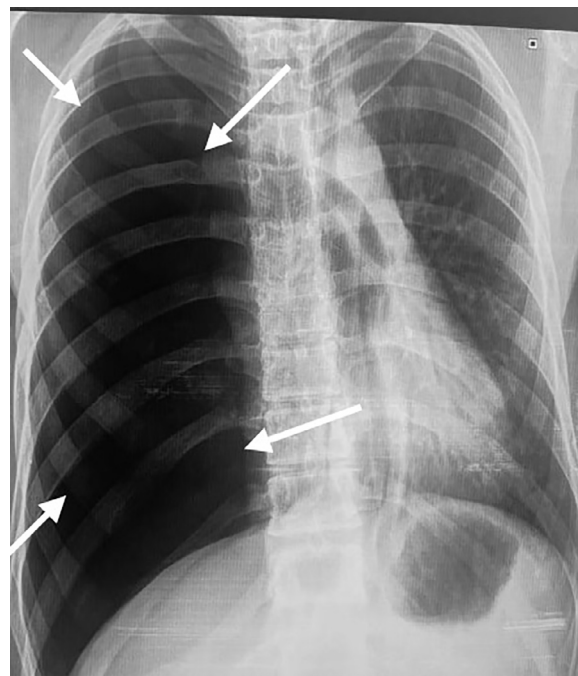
Chest radiograph demonstrating a large right-sided pneumothorax. The arrows highlight the absence of lung markings in the right hemithorax, the collapsed right lung is displaced medially, indicative of a tension pneumothorax.
